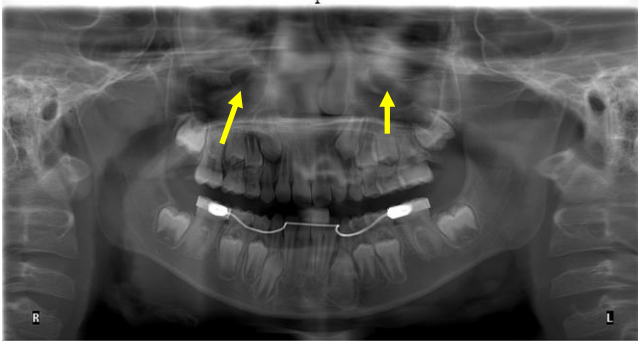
Panoramic radiograph showing bilateral unilocular ovoid shape Haller's cells (arrows).
